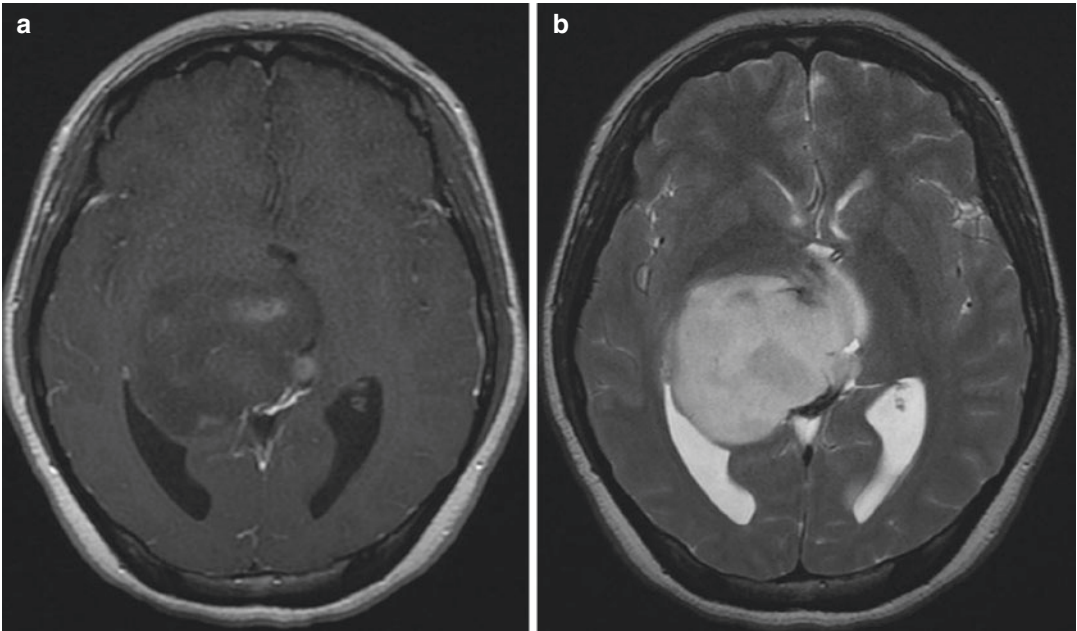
Diffuse midline glioma with histone H3-K27M mutation centered involving the right thalamus. (a) Post-contrast T1-weighted image demonstrates heterogeneous areas of enhancement. (b) T2-weighted image
